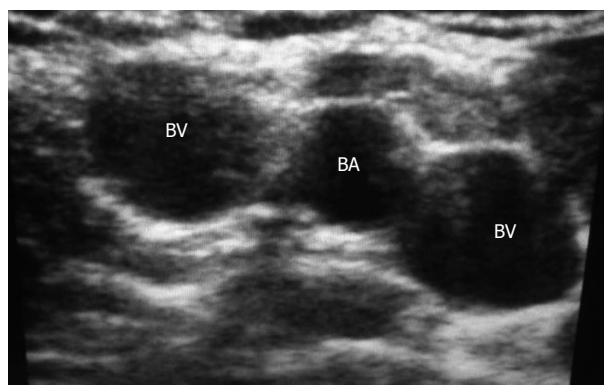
Ultrasound visualization of vessels of right upper arm: the brachial artery is the middle of two brachial veins. BA: Brachial artery; BV: Brachial veins.
